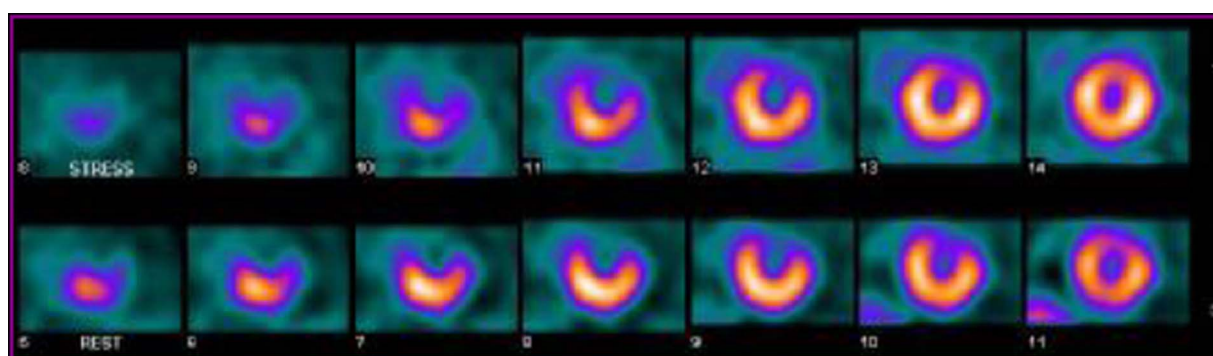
Myocardial perfusion scintigraphy (stress and rest) performed a month after the event, showing a fixed perfusion defect in the apex and anterior wall (medium-apical) and no evidence of ischaemia.
